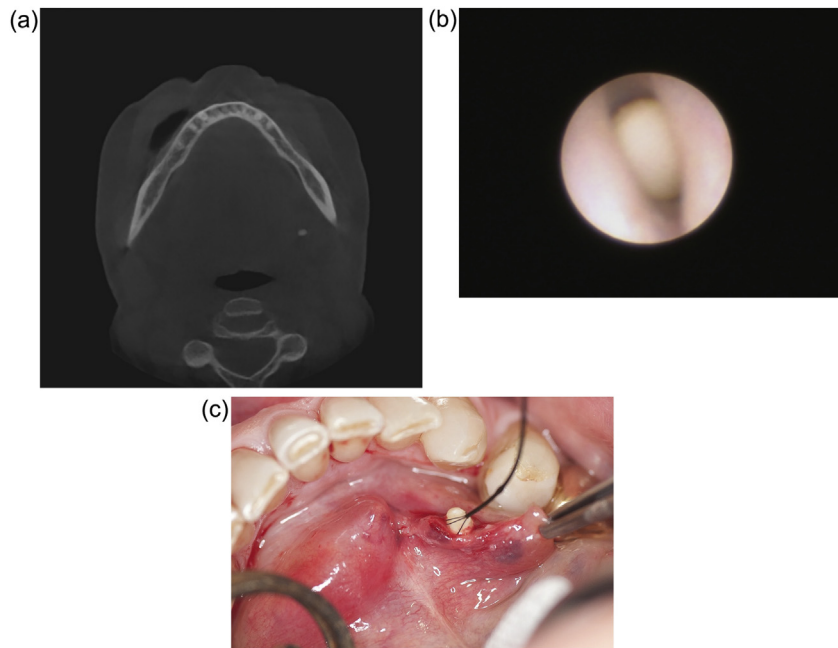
(A) CBCT scan (axial view) showing a small opacity near the hilum of the left submandibular gland, probably a salivary stone. (B) During sialendoscopy, the stone was found to be proximal to Wharton's duct. (C) Sialendoscopic wire basket retrieval of the stone: after a limited papillotomy, the stone was removed easily.
